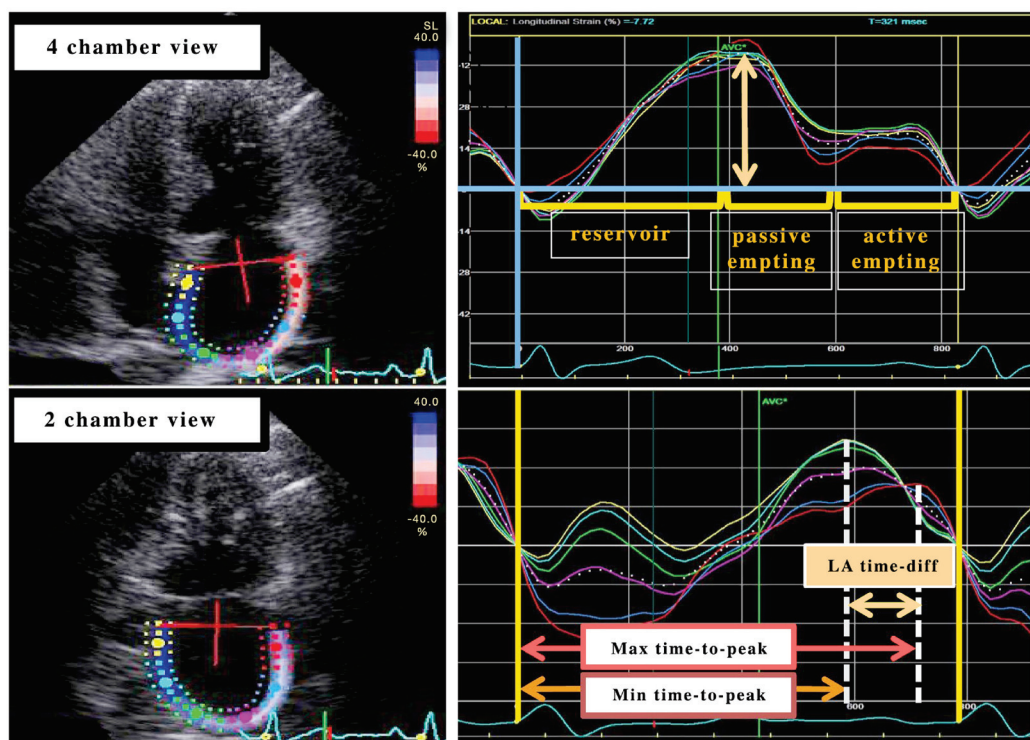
Echocardiographic analysis of left atrial (LA) strain: Phases of atrial function and dyssynchrony assessment.
